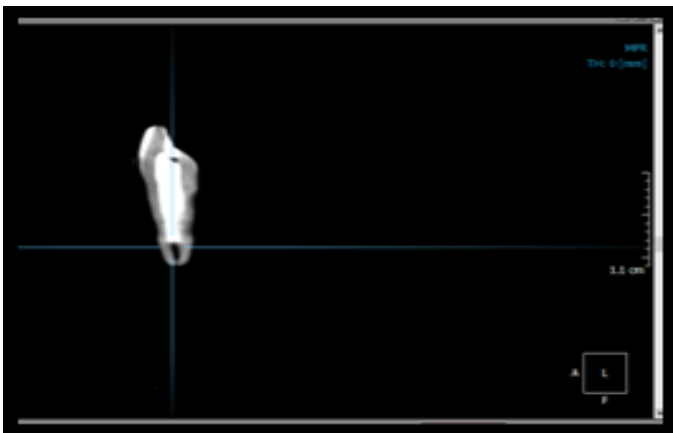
Figure b: Post - obturation volumetric analysis in CBCT scan
